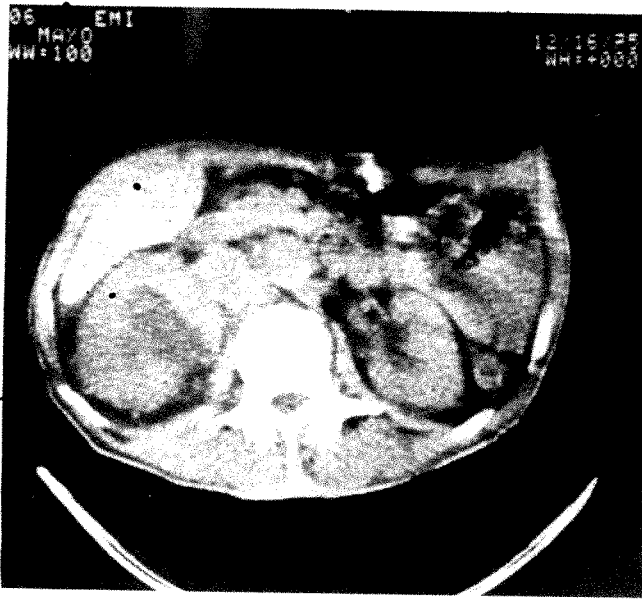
72-year-old woman with evidence of metastatic carcinoma to brain. Excretory urogram revealed 5 cm mass in lower pole of left kidney and large parapelvic mass on right. *A*, CT scan showing sharply circumscribed low density mass in central portion of right kidney. *B*, Section through low density mass in lower pole of left kidney. *C*, Injected contrast material in collecting system causes streaklike artifacts but no change in density of centrally located renal mass. *D*, No change in density of mass in lower pole of left kidney after injection of contrast material. *E*, Excretory urogram showing right parapelvic mass and left lower pole mass. Diagnosis was bilateral renal cysts.
